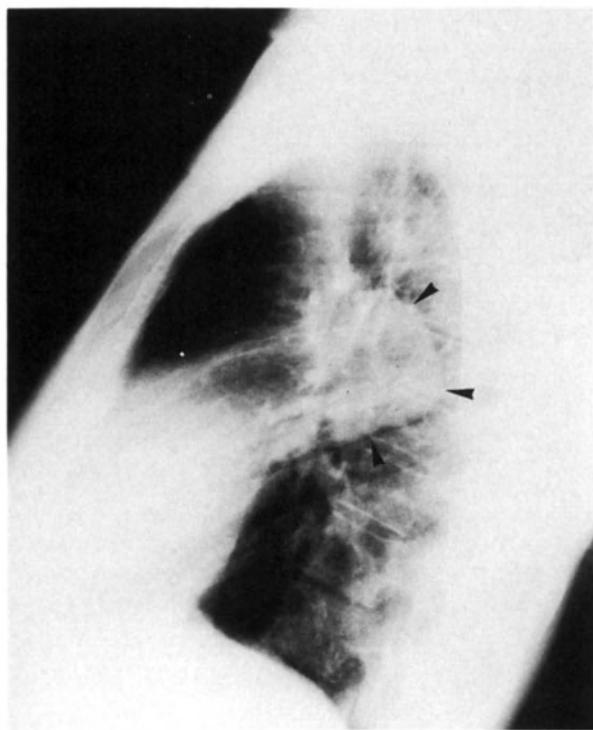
Pseudo-coarctation of aorta. A Chest radiograph suggests a left-sided mediastinal mass (*arrowheads*). B Lateral film shows typical kinking in aortic arch (*arrowheads*). C DSA confirms the diagnosis. The kink in the aorta is well demonstrated (*arrowhead*).
